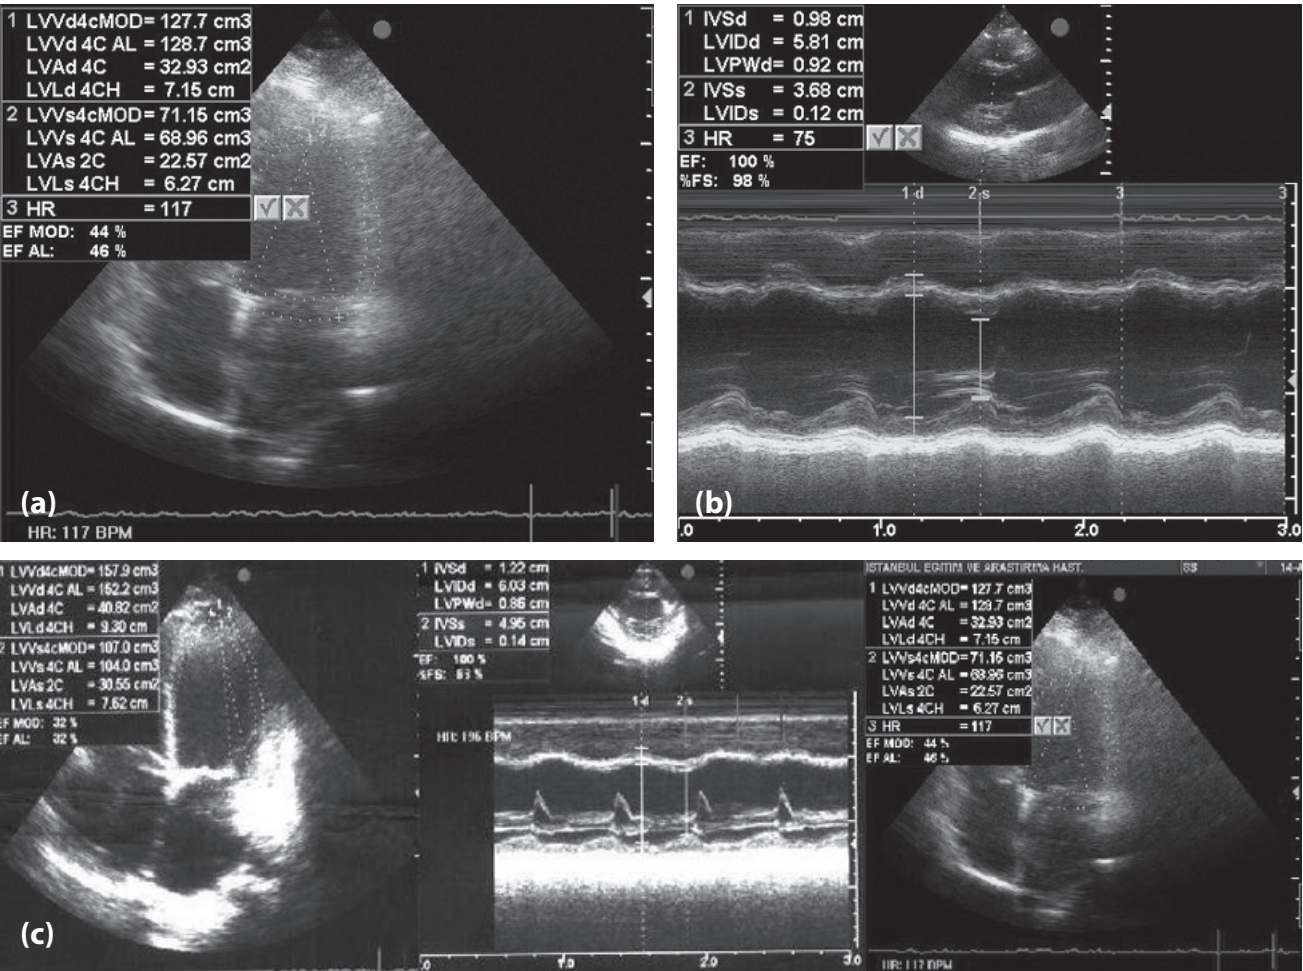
(a, b) 3rd month echocardiograms, and (c) comparison of the echocardiograms.
